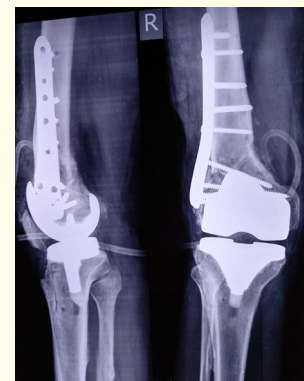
Xray radiograph (AP) and Lateral (lat) post-operative.
